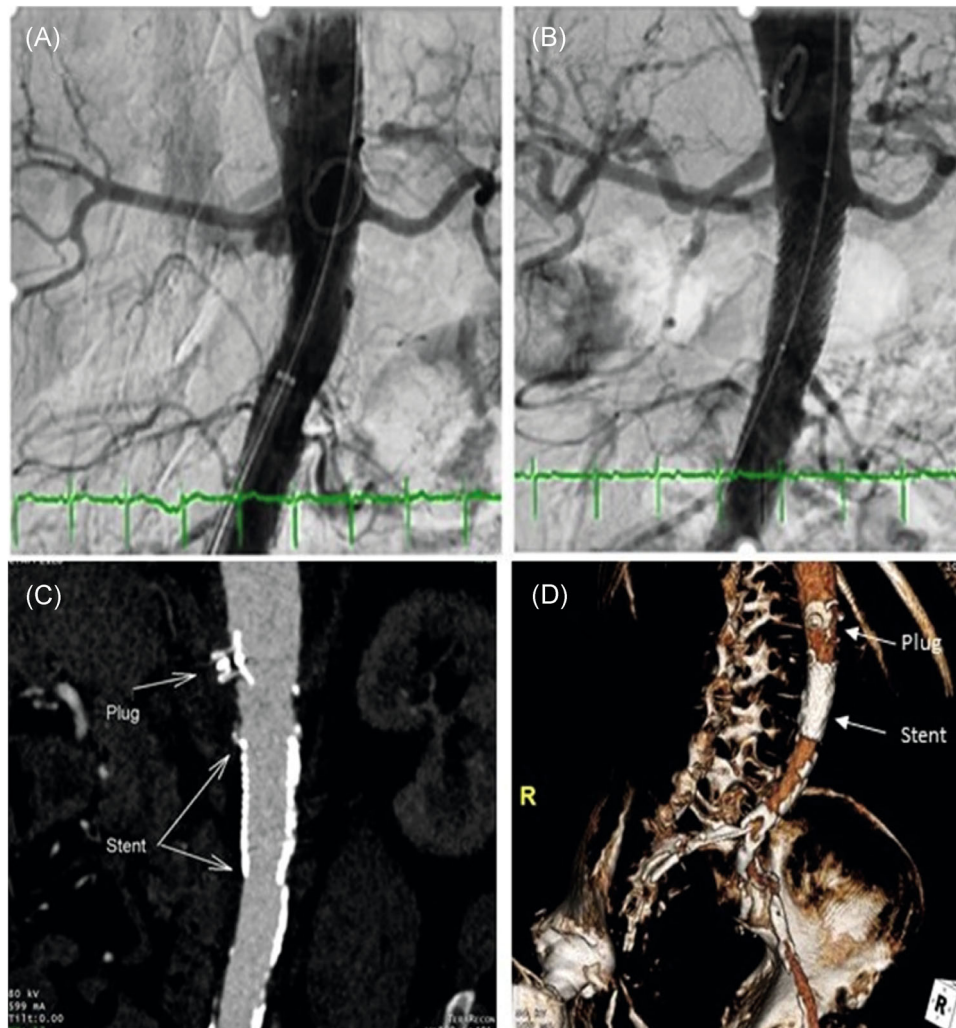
(A and B) Aortic angiography before and after percutaneous aortic stent implantation for correction of pseudoaneurysm. (C) Computerized tomography (CT) coronal plane and angiography 3D reconstruction (D) showing correct stent implantation with the exclusion of the pseudoaneurysm [Color figure can be viewed at wileyonlinelibrary.com]
